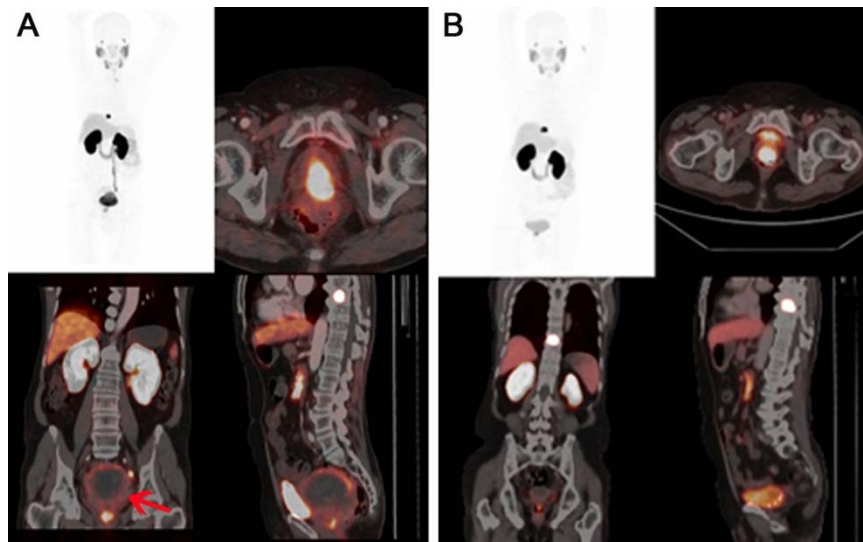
⁶⁸Ga-PSMA-PET/CT(March-2016) showing intense-avid prostatic and D9 vertebral lesions, faint uptake in large pelvic mass with central necrosis infiltrating prostate and rectum(red arrow).
